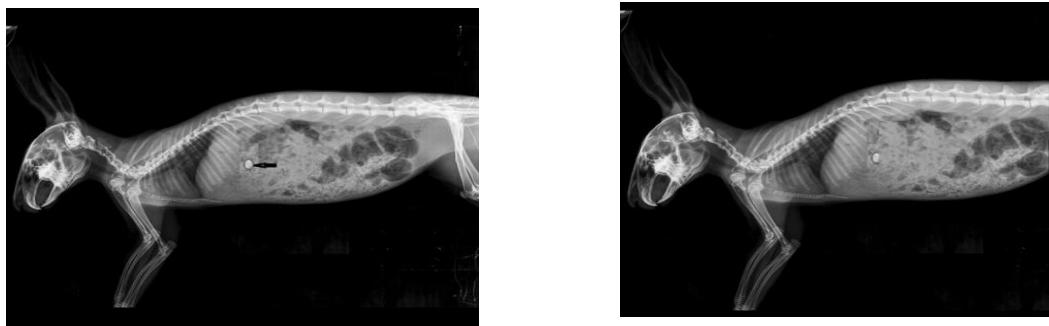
19& 20: X-ray images at 2, 4 and 7h
